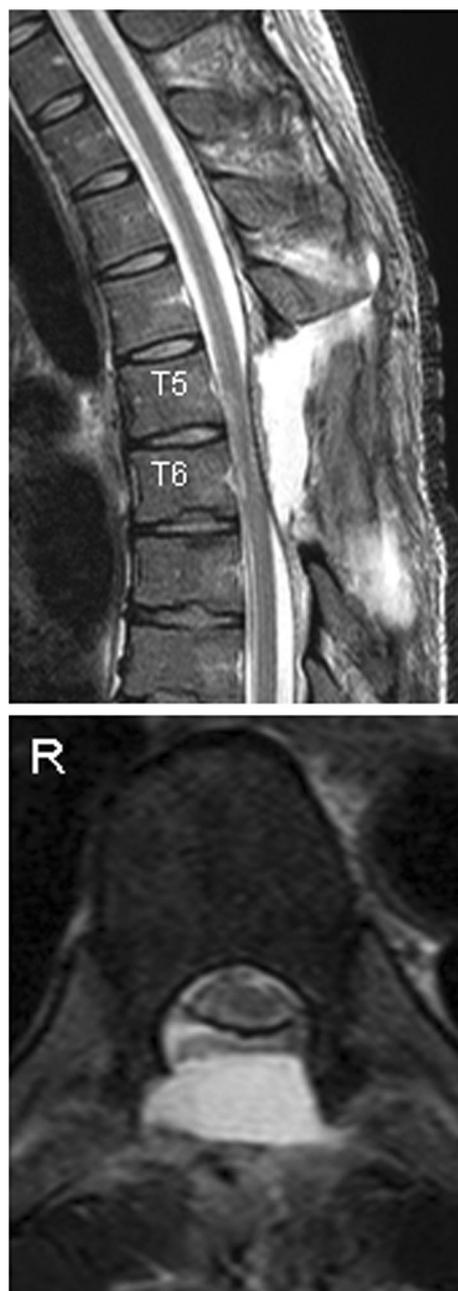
Postoperative T2-weighted MRI. Sagittal- (*upper row*) and axial images at the T5–6 intervertebral level (*lower row*) confirm restoration of the course of the cord. The subarachnoid space ventral to the cord is observed
